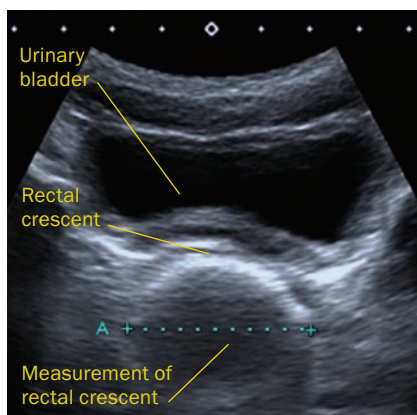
Transabdominal ultrasound showing measurement of the rectal crescent (transrectal diameter), which can support assessment of rectal distension and faecal retention.¹⁰ Adapted under a Creative Commons Attribution (CC BY) license from Lindert J et al. *Children* (Basel) 2024; 11: 921.
